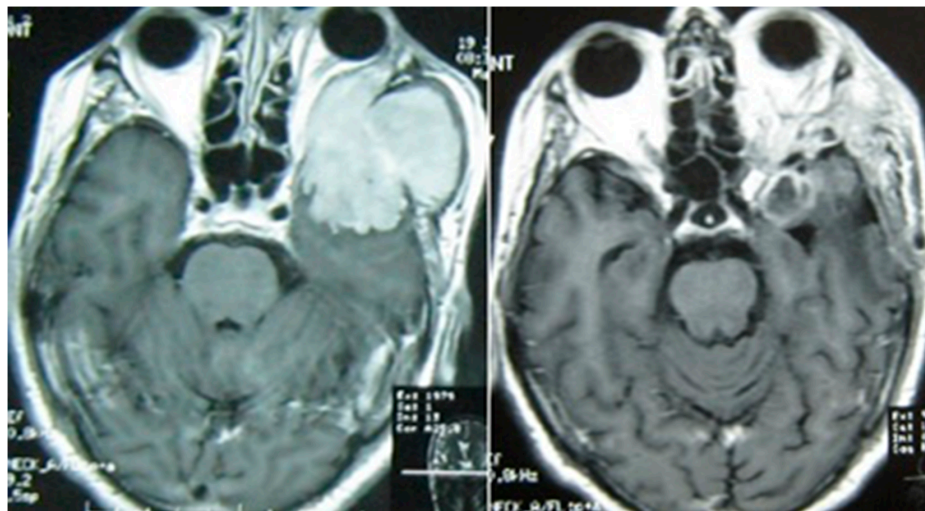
Contrast MRI of brain axial sections; left side shows huge preoperative anaplastic sphenoidal wing meningioma, and right side shows postoperative complete excision of meningioma. Source: Figure by authors.
